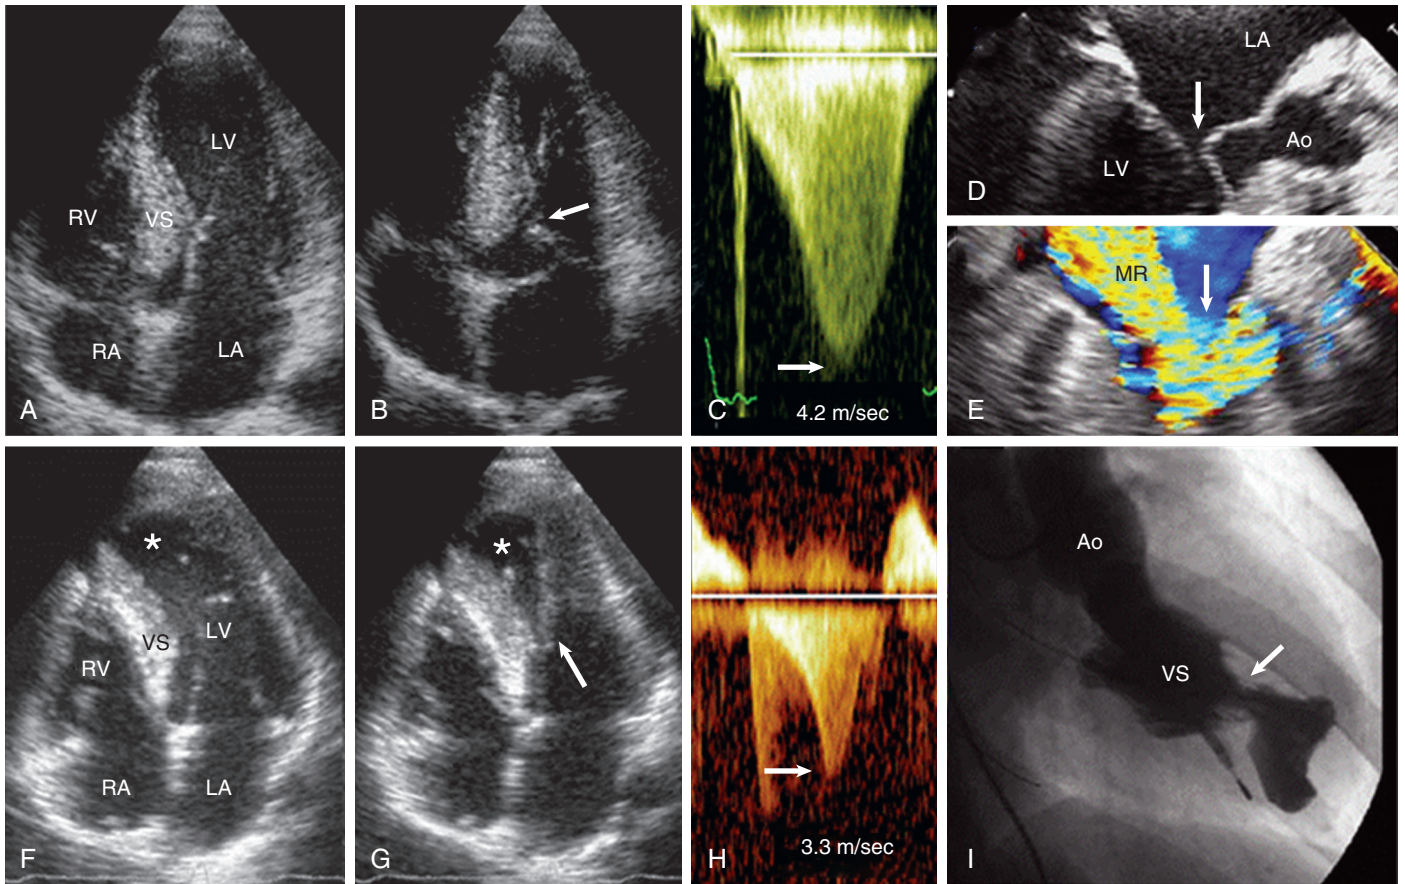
Dynamic LV outflow obstruction. A-E, Subaortic obstruction due to systolic anterior motion of the mitral valve (SAM). A, B, Echocardiographic apical four-chamber view at end-diastole and end-systole, respectively, as the anterior mitral leaflet bends acutely with septal contact (arrow). C, Continuous wave Doppler interrogation of the LV outflow tract showing the typical late-peaking waveform with velocity of 4.2 m/sec in mid-systole, estimating a 70 mm Hg gradient (arrow); D, E, Transesophageal echo plane showing incomplete mitral leaflet coaptation during SAM (arrow), producing posteriorly directed mitral regurgitation (MR) jet. F-I, Midventricular obstruction. F, G, Echocardiographic apical four-chamber view at end-diastole and end-systole, respectively, showing hypertrophied anterolateral papillary muscle appearing to insert into anterior mitral leaflet, creating midventricular muscular obstruction (arrow). H, Continuous wave Doppler interrogation of LV outflow tract showing late-peaking waveform with velocity of 3.3 m/sec estimating a 45 mm Hg gradient (arrow). I, LV ventriculogram showing hour-glass contour of chamber associated with midventricular obstruction (arrow). Ao = aorta; LA = left atrium; LV = left ventricular; RA = right atrium; RV = right ventricle; VS = ventricular septum. (From Yacoub MH, El-Hamamsy I, Said K, et al: *The left ventricular outflow in hypertrophic cardiomyopathy: from structure to function*. *J Cardiovasc Transl Res* 2:510, 2009 with permission from Springer; and Olivetto I, Girolami F, Nistri S, et al: *The many faces of hypertrophic cardiomyopathy: from developmental biology to clinical practice*. *J Cardiovasc Transl Res* 2:349, 2009.)
